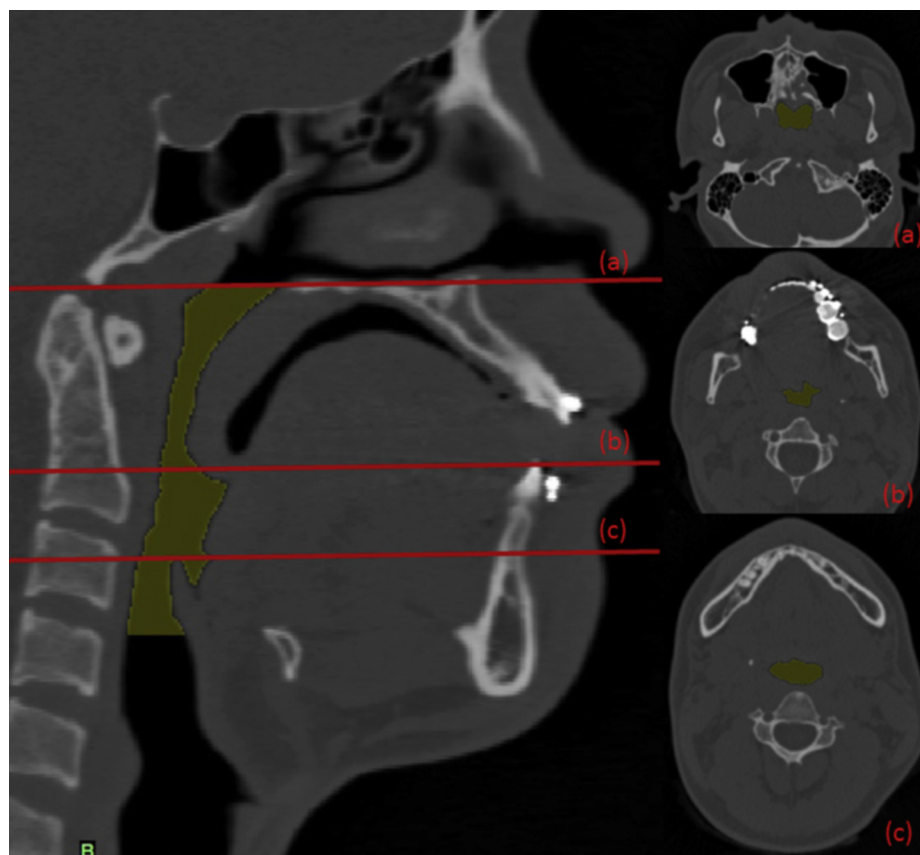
Air-mode CT images (sagittal and axial views) of a patient with OSAS showing the landmarks used for airway morphologic measurements. a) Area at the hard palate level, b) area at the uvular tip level, c) area at epiglottic tip level.
